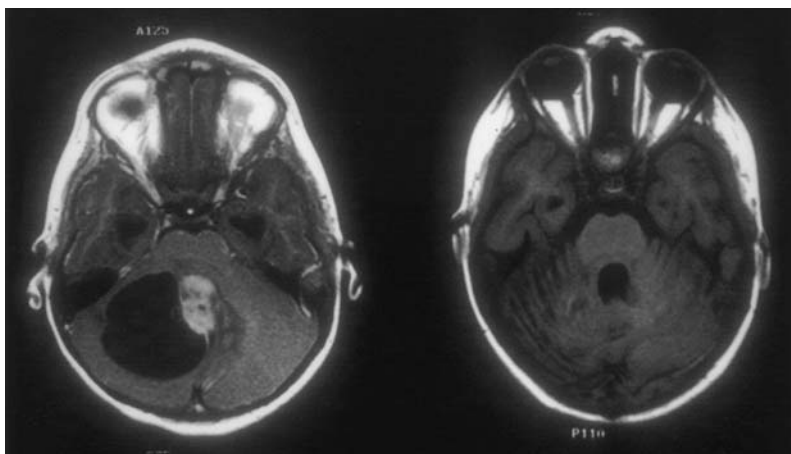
(Left) Axial gadolinium-enhanced MRI (T1), showing a vermillion juvenile pilocytic astrocytoma. Typical of pilocytic astrocytomas, the majority of the mass effect is due to the large cyst, while the enhancing solid portion contributes much less. (Right) Post-operative axial MRI (T1) after gross total resection of the solid portion of the astrocytoma. As the cyst wall is not composed of tumor cells, it is unnecessary, and potentially morbid, to resect the cyst wall.
